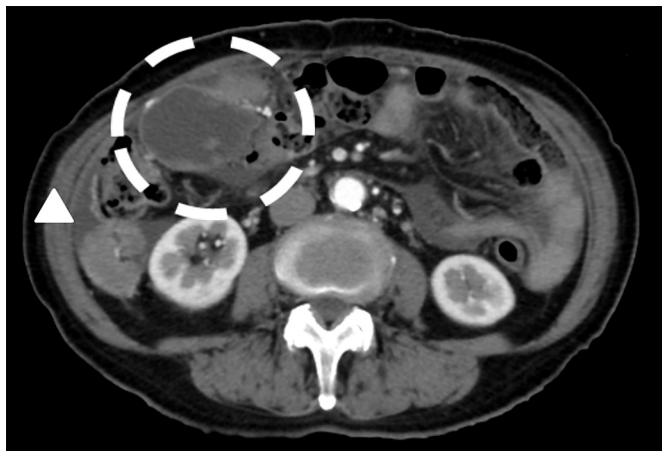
Abdominal CT was taken just before Patient's first visit to our clinic after the surgery. Metastatic mass in peritoneum and slight ascites (Δ) was detected.
